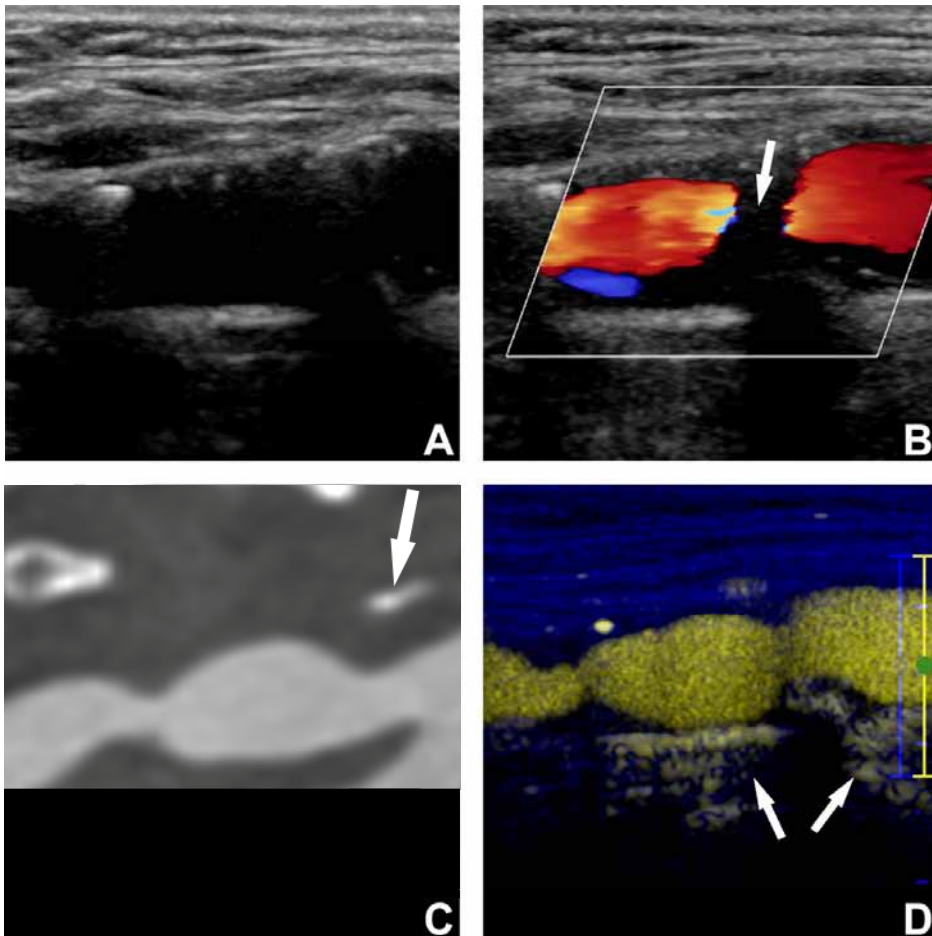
Longitudinal B-mode ultrasound (A), CDUS (B), CTA (C), and CEUS (D) images of carotid plaque classified as irregular using both CEUS and CTA. Calcification of carotid artery (C, arrow) caused acoustic shadow that hindered accurate color Doppler evaluation (B, arrow). A clear evaluation is possible with CEUS (D), providing information similar to that obtained with CTA (C). The enhancement underneath the vessel (D, arrows) is a pseudoenhancement artifact.
